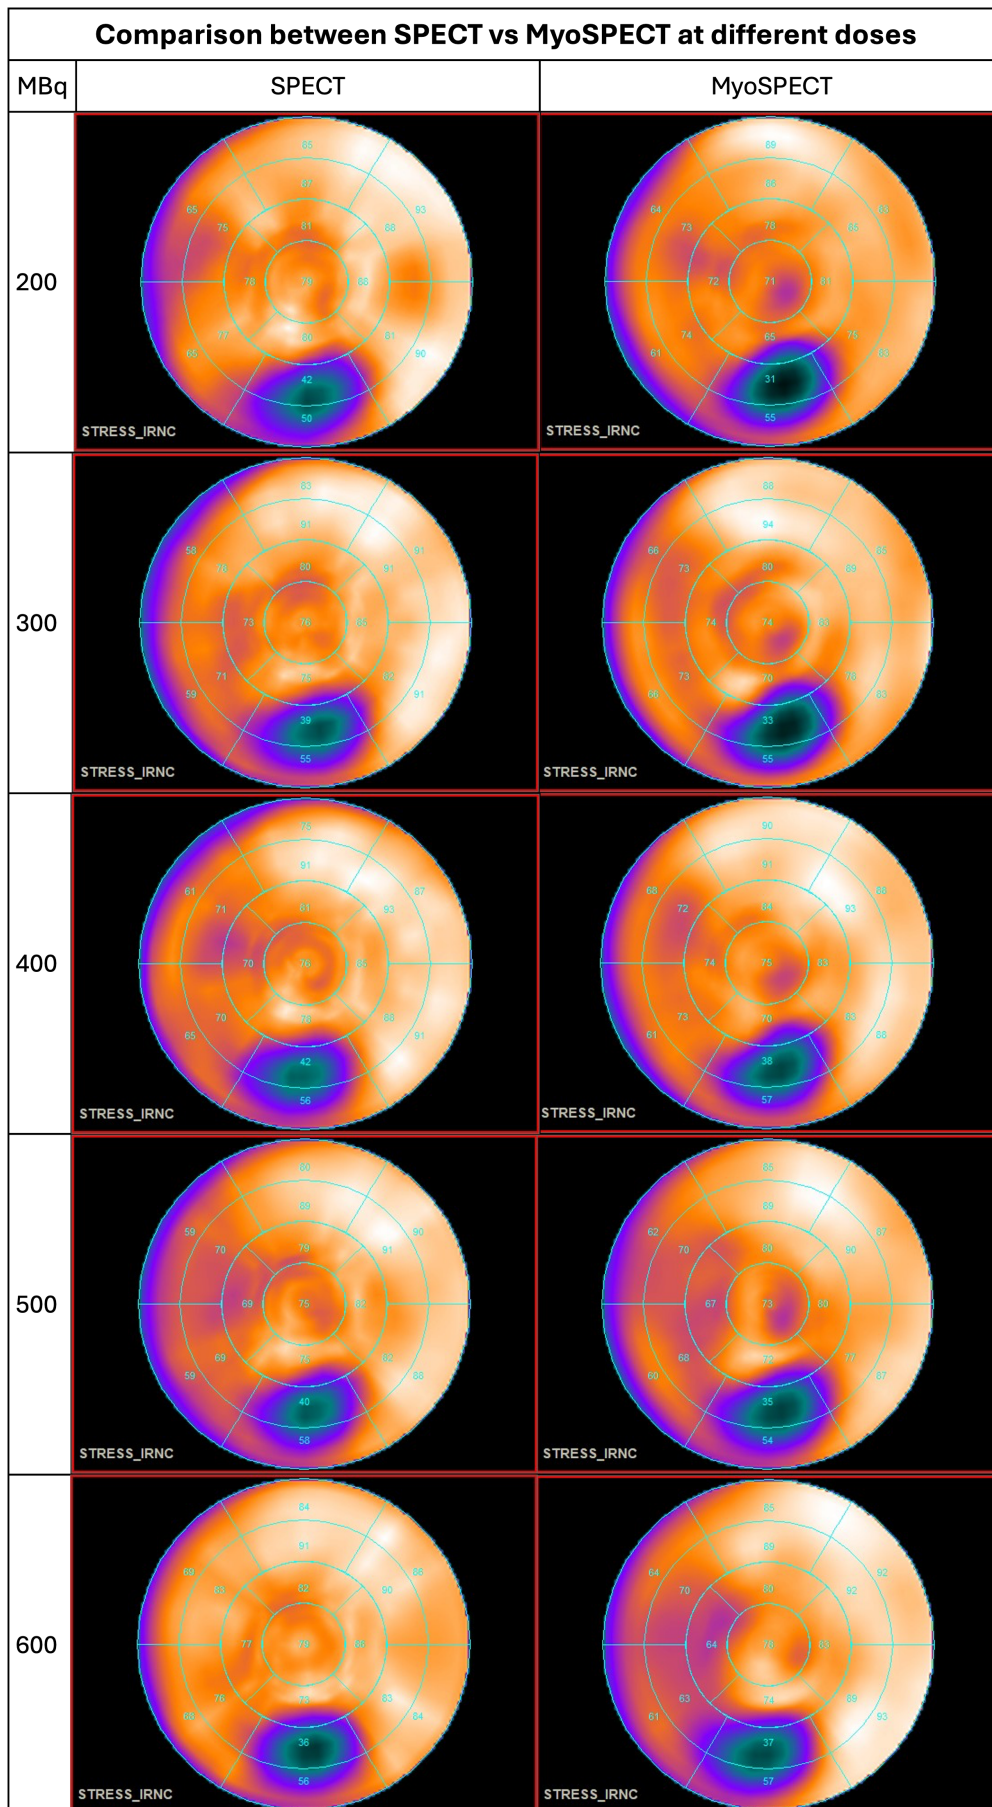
Comparison of SPECT and MyoSPECT through polar maps of the segments
